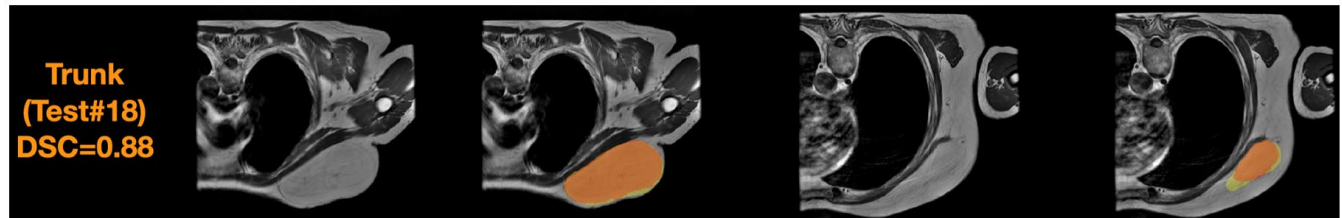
Example SL ensemble predictions (red) and tumor delineations (yellow) per tumor location overlaid on the T1-weighted MR images giving orange color for the correctly predicted tumor region. First two columns represent the central image slices of the tumors without and with the delineations and predictions, respectively, whereas the second two columns represent the edge image slices of the tumors. The predictions are often worse in the edge slices than in the central slices of tumor.
